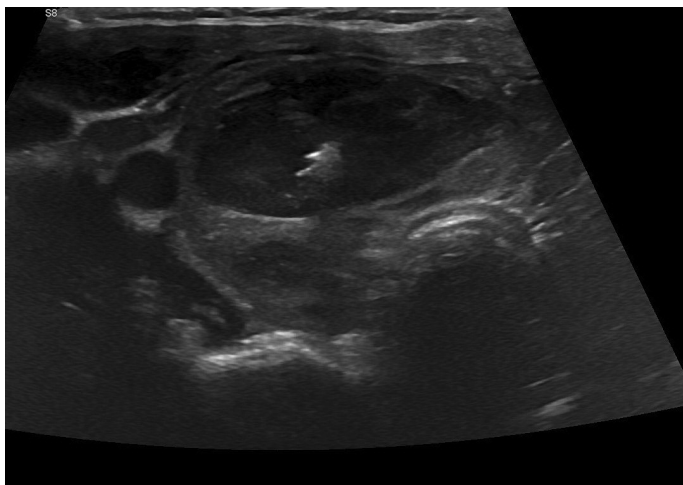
Ultrasound guided core needle biopsy
